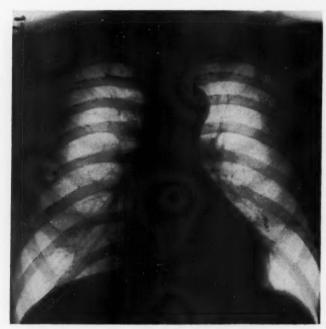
Chest x-ray, 1949.
